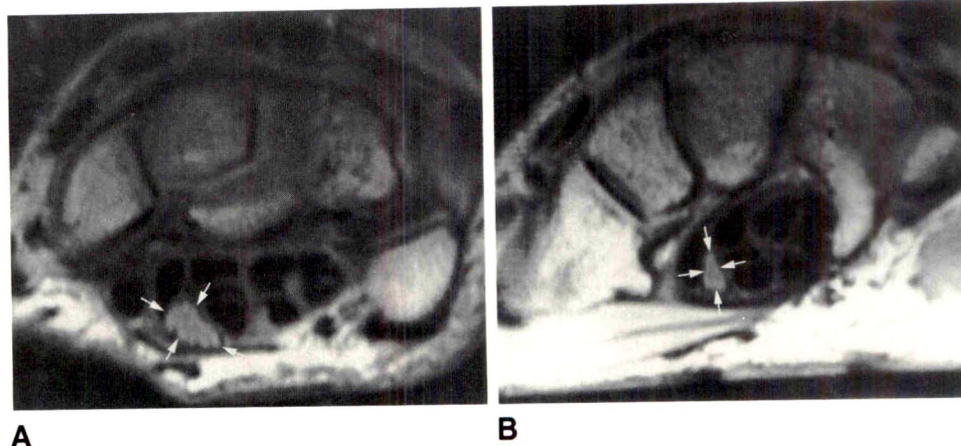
Segmental swelling of median nerve (arrows). Axial MR images (TR 2000, TE 20) at levels of pisiform (A) and hook of hamate (B). Left wrist viewed toward elbow with palm down. Note enlargement of nerve proximally (A) compared with normal caliber of nerve distally (B).
